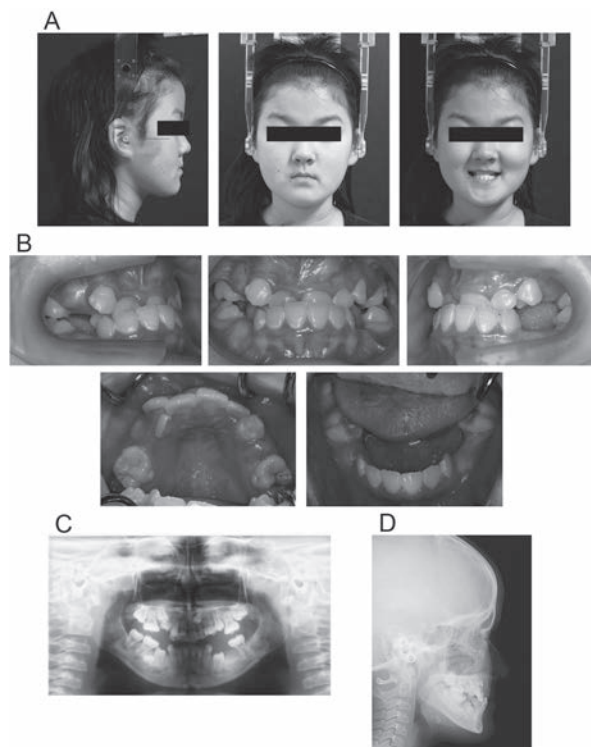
Pre-treatment records (age: 12 years and 4 months). A, Facial photographs. B, Intraoral photographs. C, Panoramic radiographs. D, Lateral cephalograms.
